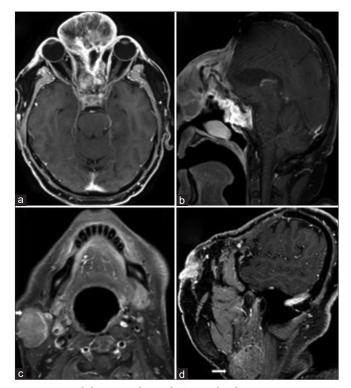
Preoperative (a and b) and postoperative (c and d) gadolinium-enhanced T1-weighted magnetic resonance imaging of the first surgery (in 2016) in our institution. (a and b) Voluminous polylobulated expansive brain tumor with skull base compromise, orbital and nasal invasion. (c and d) Imaging control of gross total resection of the tumor.
